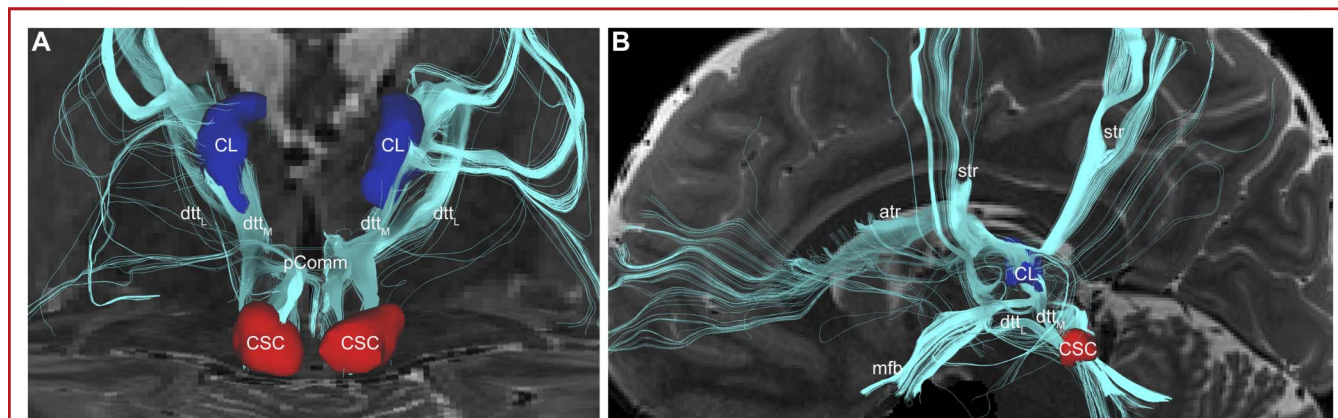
Diffusion MRI tractography of the ascending reticular activating system in vivo, delineated by the human cuneiform–subcuneiform complex in the midbrain. Deterministic tractography from a 7T acquisition was performed in an individual subject from the HCP S1200 cohort ($b = 1000, 2000 \text{ s/mm}^2$, $TR/TE = 7000/71.2 \text{ ms}$, and slice thickness = 1.05 mm isotropic). A, Coronal and B, sagittal sections of the projections from the reticular formation to the intralaminar nuclei of the thalamus. The CSC was used as the seed, and the CL nucleus of the thalamus was the target. Tractography delineated the medial (dtl_M) and lateral (dtl_L) subdivisions of the dorsal tegmental tract. $pComm$ fibers are visualized in A, at the level of the midbrain. In B, no termination masks were used to delineate the global white matter tracts that are projections from the dtl . Labeled neuroanatomic landmarks are mfb , atr , and str . atr , anterior thalamic radiations; CL, central lateral; CSC, cuneiform/subcuneiform complex; dtl_M , delineated the medial; dtl_L , delineated the lateral; HCP, Human Connectome Project; mfb , medial forebrain bundle; $pComm$, posterior commissure; str , superior thalamic radiations TE, echo time; TR, repetition time.
